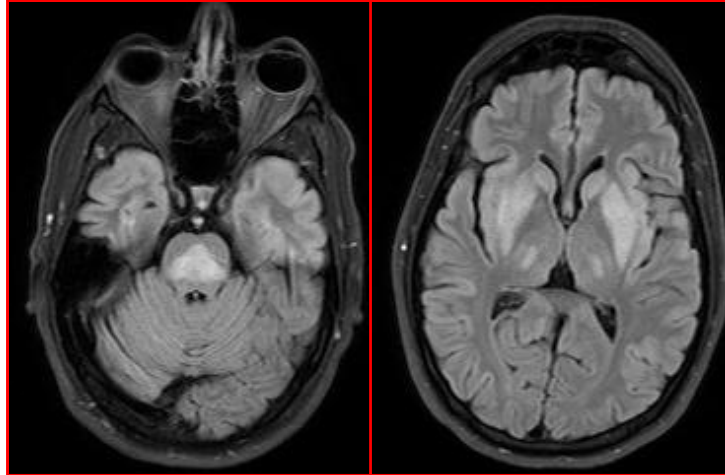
Follow up MRI of the brain with and without contrast 5 days later showed enlargement of the pons lesion and extrapontine lesions
